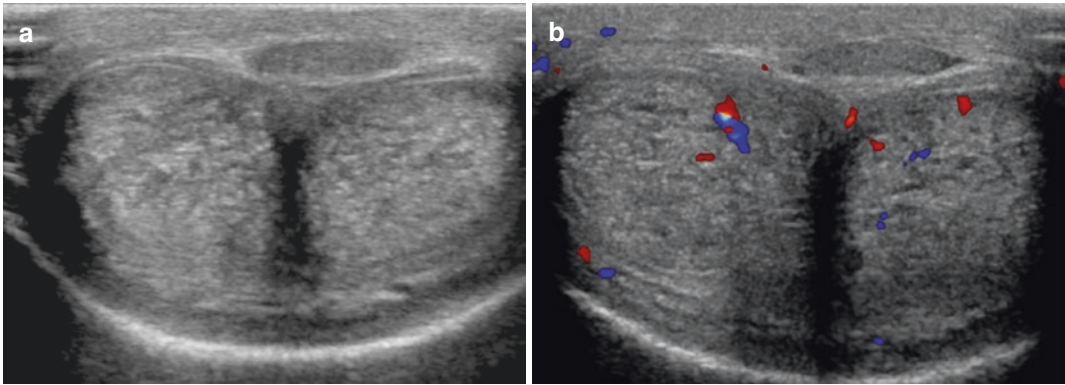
Low-flow priapism lasting since 3 days. (a) Greyscale ultrasonography shows increased echogenicity of the cavernosal tissue, consistent with oedema. (b) Colour Doppler interrogation shows
